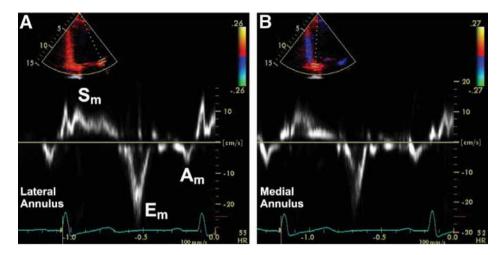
Tissue Doppler imaging (TDI). Tissue Doppler assesses myocardial velocities during the cardiac cycle. Doppler shift measured at the lateral (A) and septal annulus (B) are shown. Systolic shifts (S_m) are upward (positive). Shifts away from the transducer (E_m and A_m), reflecting early and late diastolic velocities, are downward (negative).
